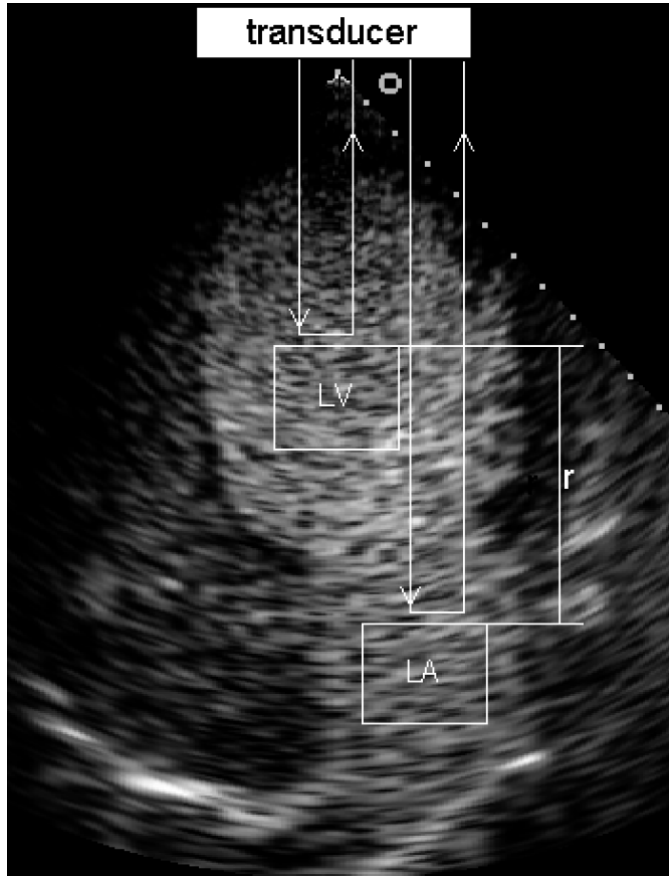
Transthoracic, four-chamber view. Two ROIs are placed on the LV and LA for the IDC measurement. A simplified representation of the ultrasound wave paths to the LV and LA ROI are shown as well as the different distance r from the transducer.
